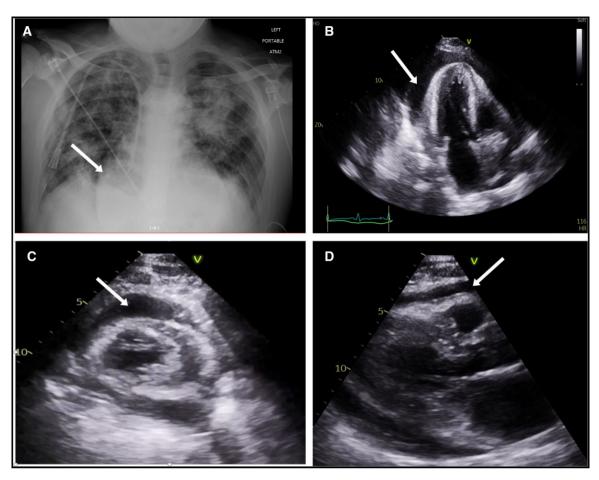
Plain chest radiograph and echocardiogram images. (A) Plain chest radiograph showing diffuse airspace opacities with enlarged cardiac silhouette. (B) Echocardiogram four-chamber view showing large anterior pericardial effusion. (C) Echocardiogram short-axis view at the level of the apex showing large circumferential pericardial effusion. (D) Echocardiogram parasternal long view showing right atrial collapse during early systole suggestive of tamponade physiology
